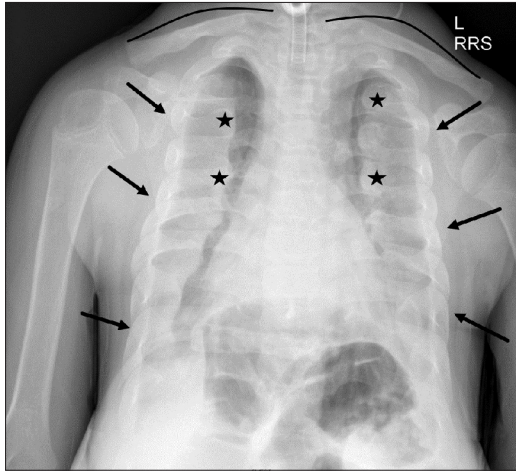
Chest radiograph of a 12-year-old male with Jeune Syndrome shows short rib dysplasia, bell-shaped narrow chest and hypoplastic lungs (black arrows), irregular costochondral junctions (black stars), and handlebar clavicles (black lines)
